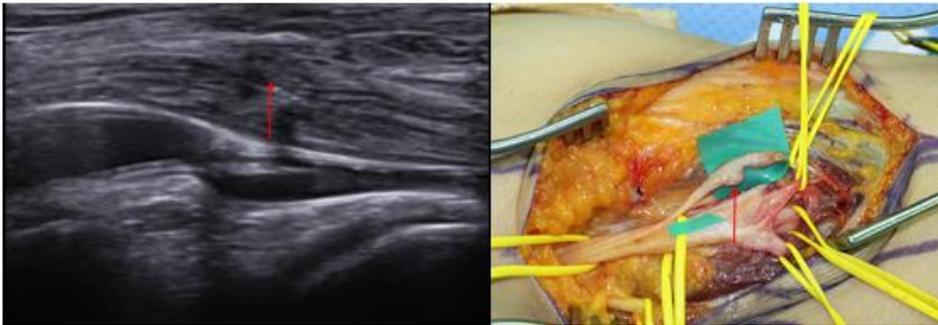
Ultrasonographic findings and intraoperative findings. Neuroma(arrow) of medial sural cutaneous nerve.
